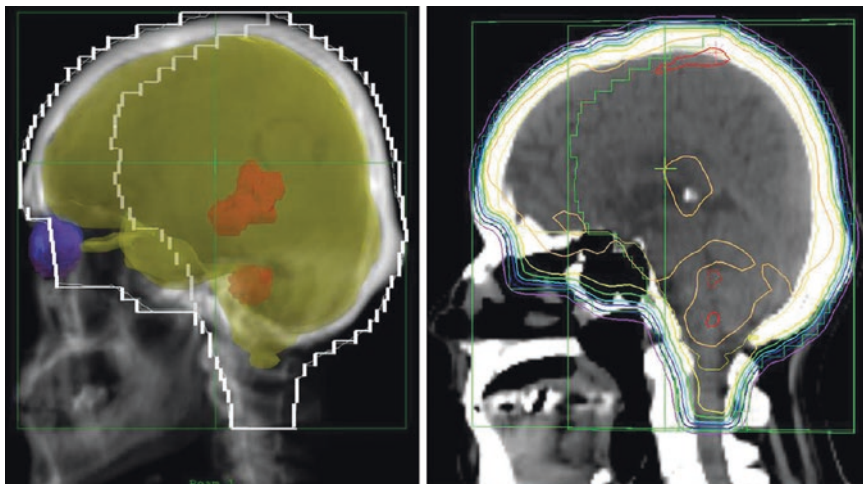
Whole-brain radiotherapy. Two slightly angled laterally opposed 6 MV X-ray beams were used in the field-in-field technique. The GTV, a Gd-enhanced area (*red*), the brain parenchyma (*yellow*), eyeball (*violet*), and lens (*blue*) are superimposed on the beam's-eye-view (*left panel*). The *right panel* shows the dose distribution in a sagittal plane. Isodose (90%, 95%, 100%, and 105%) lines are drawn in *green*, *yellow*, *orange*, and *red*, respectively. In the course of 3 weeks, a total dose of 30 Gy was delivered in 15 fractions to the whole brain
